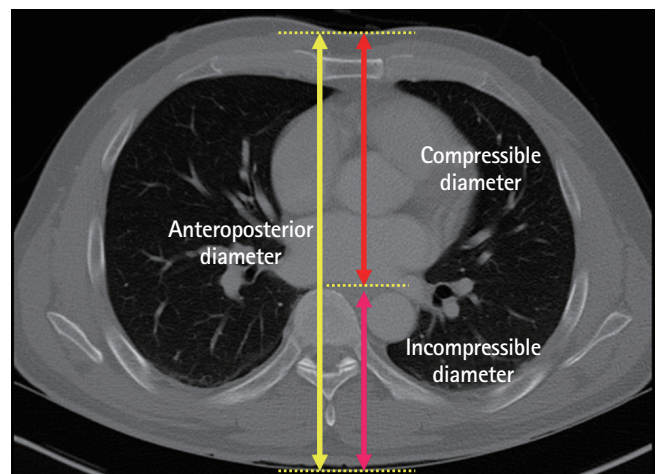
Computed tomography scan demonstrating axial image at the mid sternal level and method for calculating compressible, incompressible diameter and antero-posterior diameter. We calculated the compressible diameter by measuring a line drawn perpendicularly from the skin anteriorly to the anterior vertebral body.
